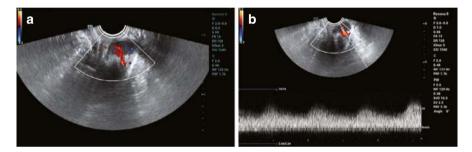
(a) Color Doppler ultrasound image of cervical cancer demonstrating abundant blood flow in a dendritic pattern. (b) Spectral Doppler ultrasound showing a low-resistance arterial spectrum
